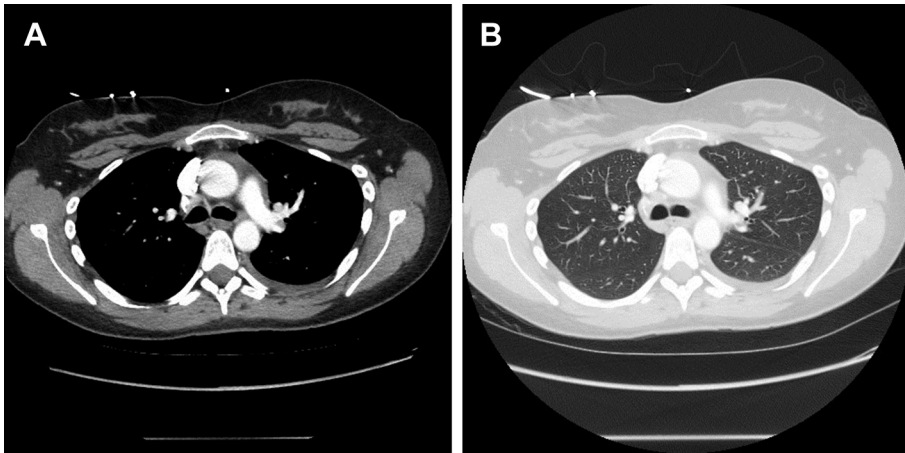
CT scan of the chest showing a small left pleural effusion (A) with low lung volumes (B).
